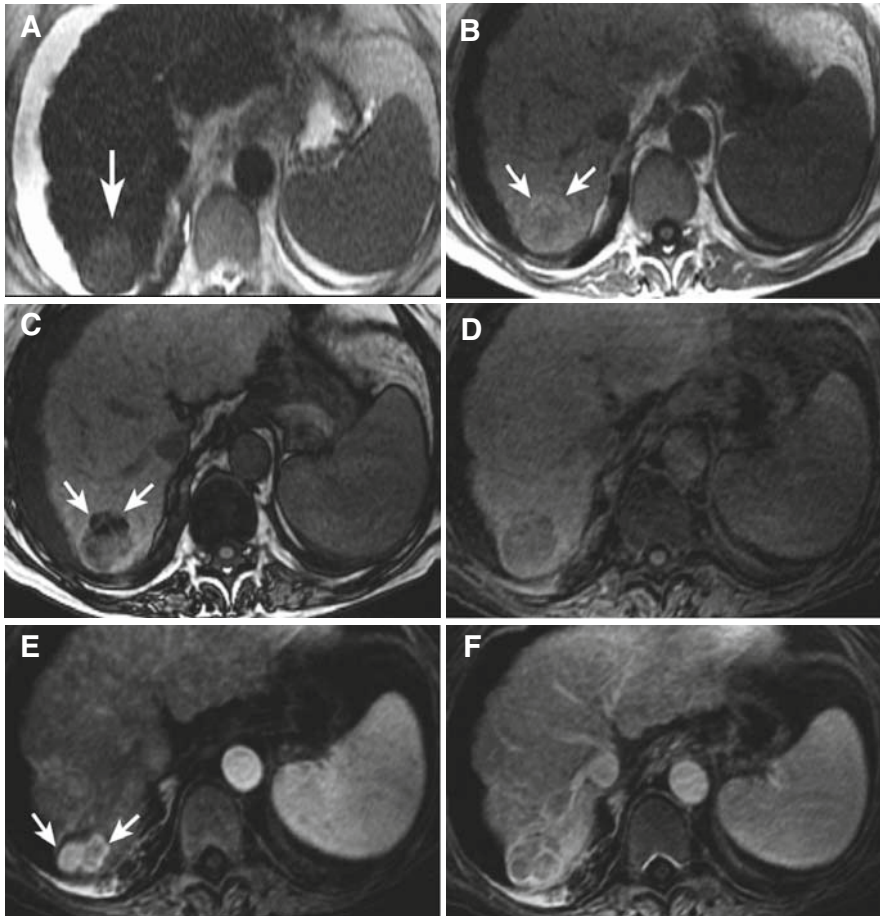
HCC with many typical MRI features. A. T2-weighted image shows HCC as high signal intensity (*arrow*). B. T1-weighted image in-phase (water plus fat) shows that most of HCC has similar intensity to remainder of liver, other than increased signal of anterior crescentic portion (*arrows*). C. T1-weighted image opposed-phase (water–fat cancellation) shows that HCC lost signal relative to other tissues, indicating lipid content. The anterior crescentic portion (*arrows*) has highest fat content and has therefore lost the most signal. D. T1-weighted fat-suppressed image shows the HCC as less signal than the remainder of liver. E. As in D, immediately after intravenous injection of gadolinium contrast agent. Hypervascular nodules within the HCC show strong enhancement (*arrows*). F. As in E, about 1 minute later. The HCC is now less intense than liver, with a multinodular appearance.
